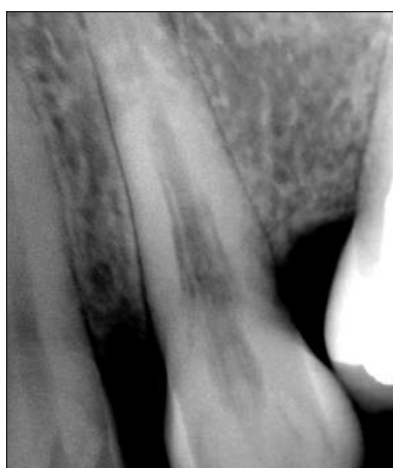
The extracanal invasive resorptive lesion in this maxillary cuspid has the radiographic appearance of radiolucent lines running parallel to the canal space on both the mesial and distal.
